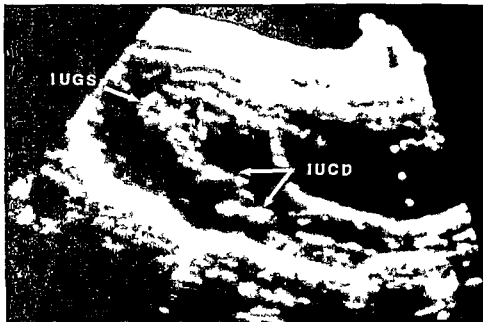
16 Sonogram (Sagittal section) Threatened abortion Intrauterine gestational sac (IUGS) in fundus with intrauterine contraception device (IUCD) in lower portion of uterus
